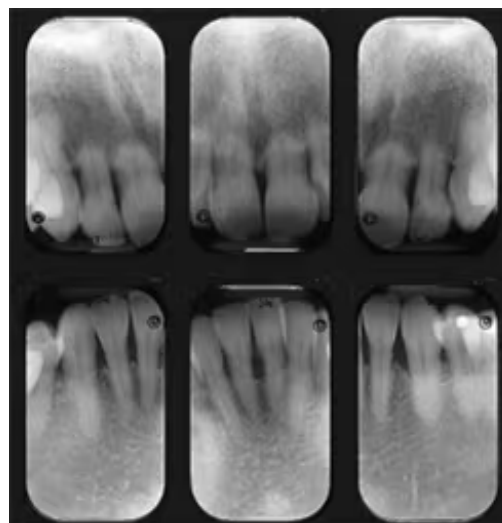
Anterior Periapical Images Depicting Root Resorption
